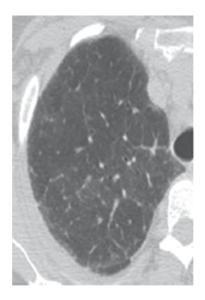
A 56-year-old female with sarcoidosis. CT of the chest demonstrates intralobular septal thickening in the right upper lobe.
